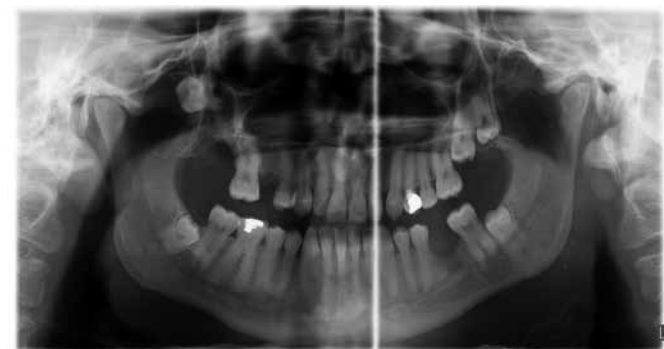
Panoramic radiograph of the displaced tooth taken during the surgery.
